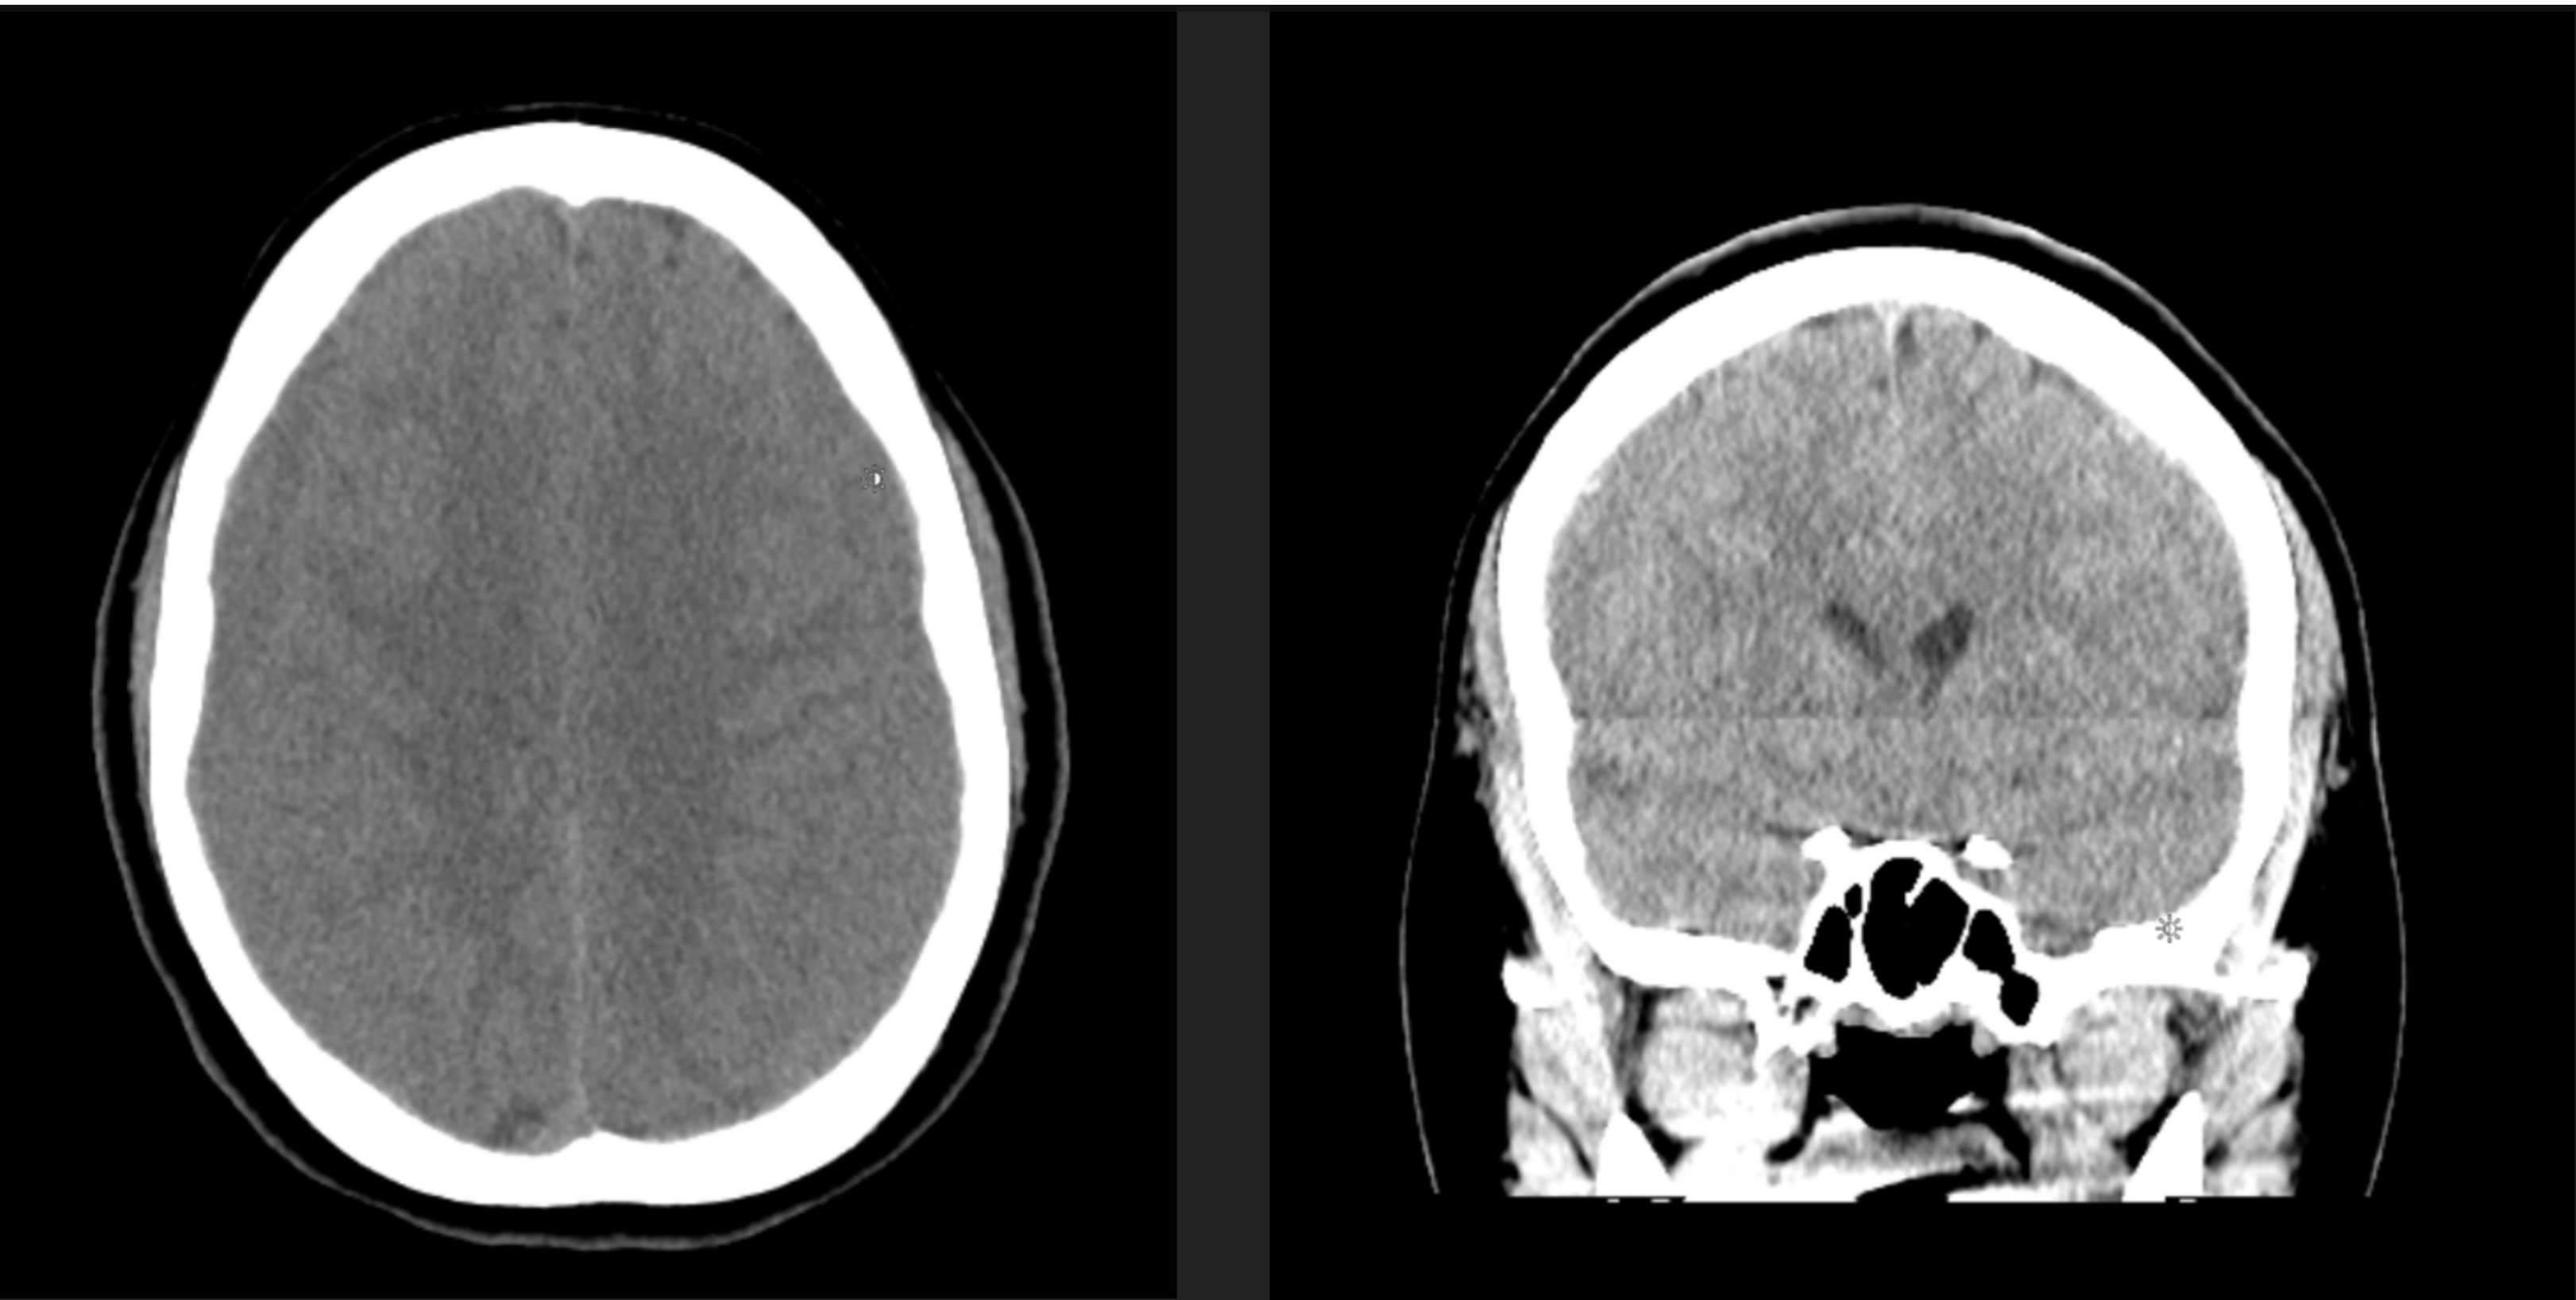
CT Head. Bilateral subdural hematomas and mild cerebellar tonsillar ectopic. Findings favored to reflect sequela of intracranial hypotension.
